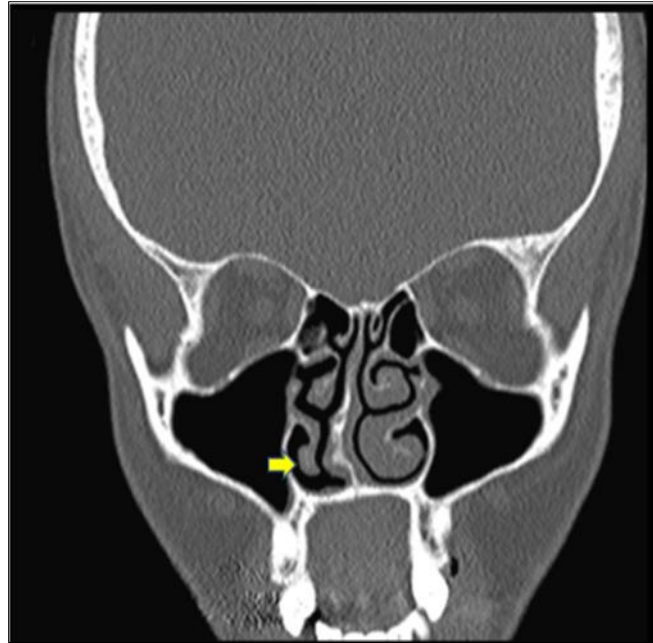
Coronal CT section showing right sided paradoxical inferior turbinate (Yellow arrow)
